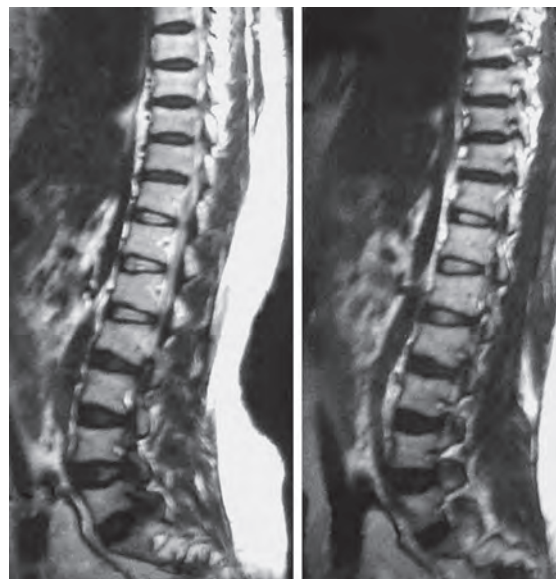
MRI sagittal view of a patient of achondroplasia showing severe canal stenosis
